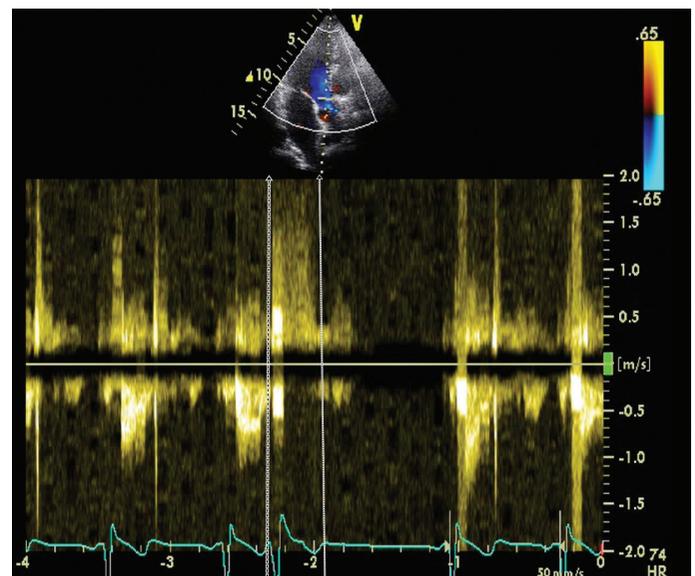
Continuous wave Doppler echocardiography image showing the flow through the aortic valve. The forward flow ceases during premature ventricular systole, and the reverse flow accentuates but does not continue during the whole diastole (premature ventricular systole between vertical arrows). The diastolic reverse flow is barely observed during a normal sinus beat
